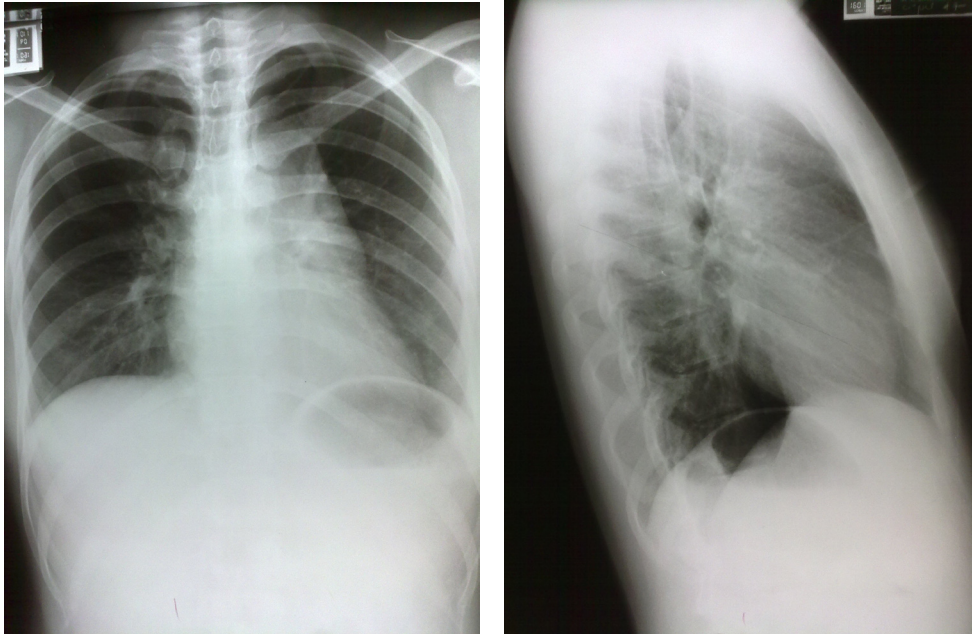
Chest X-ray PA and Lateral Views of a 19 y. o. female with mediastinal mass. Chest radiograph shows lobulated soft tissue density obscuring the aortic knob and extending down to the left atrial appendage, and appears to be located in the anterior mediastinum on lateral view
